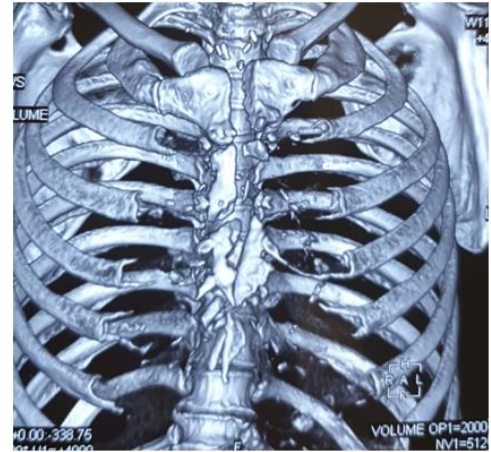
3D reconstructed CT chest.
